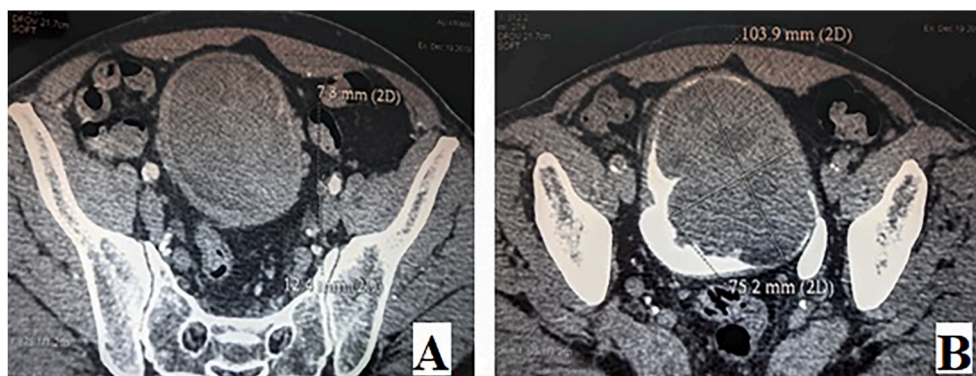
Contrast Abdominal CT Scan (A) with excretory phase (B) showing a large expansive 100 mm masse on the left bladder wall.
